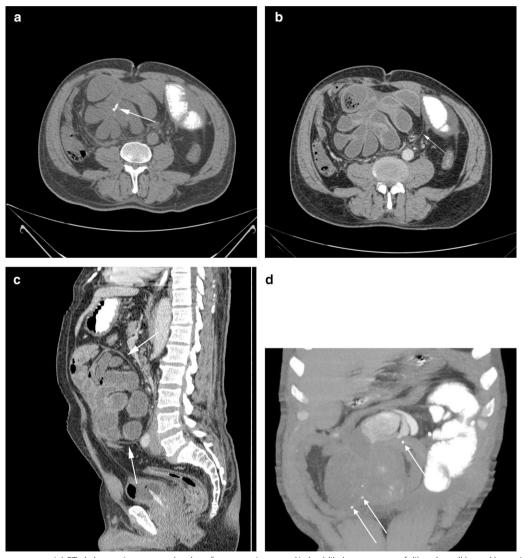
a Non-contrast axial CT abdomen images on the day of presentation reveal 'whorl-like' appearance of dilated small bowel loops in right iliac fossa region with central chunky calcification (annotated by white arrow). No transit of oral contrast noted through clumped-up small bowel loops. b Axial contrast-enhanced CT abdomen image showing thick, peripheral membranous structure around the 'whorl-like' formation of dilated bowel loops (annotated by white arrow). c Sagittal contrast enhanced CT abdomen image shows thick peripheral membrane at posterosuperior and inferior aspect of cocoon abdomen (annotated by white arrows). d Thick MIP coronal reformation of CT abdomen showing multifocal punctate peritoneal calcification (annotated by white arrows)
